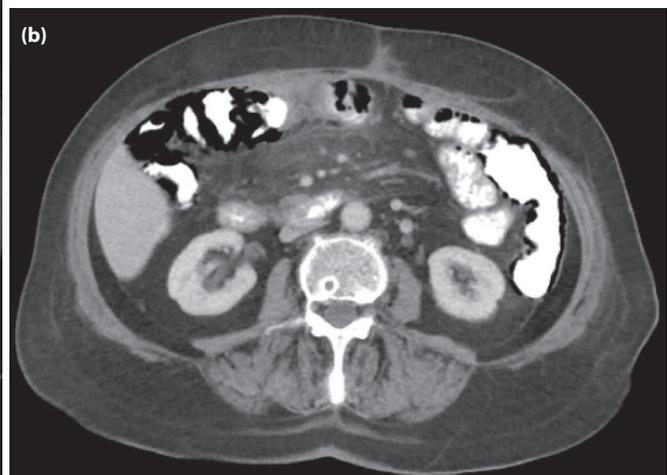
Abdominal (a) radiograph and (b) computed tomography (CT) at initial presentation.
